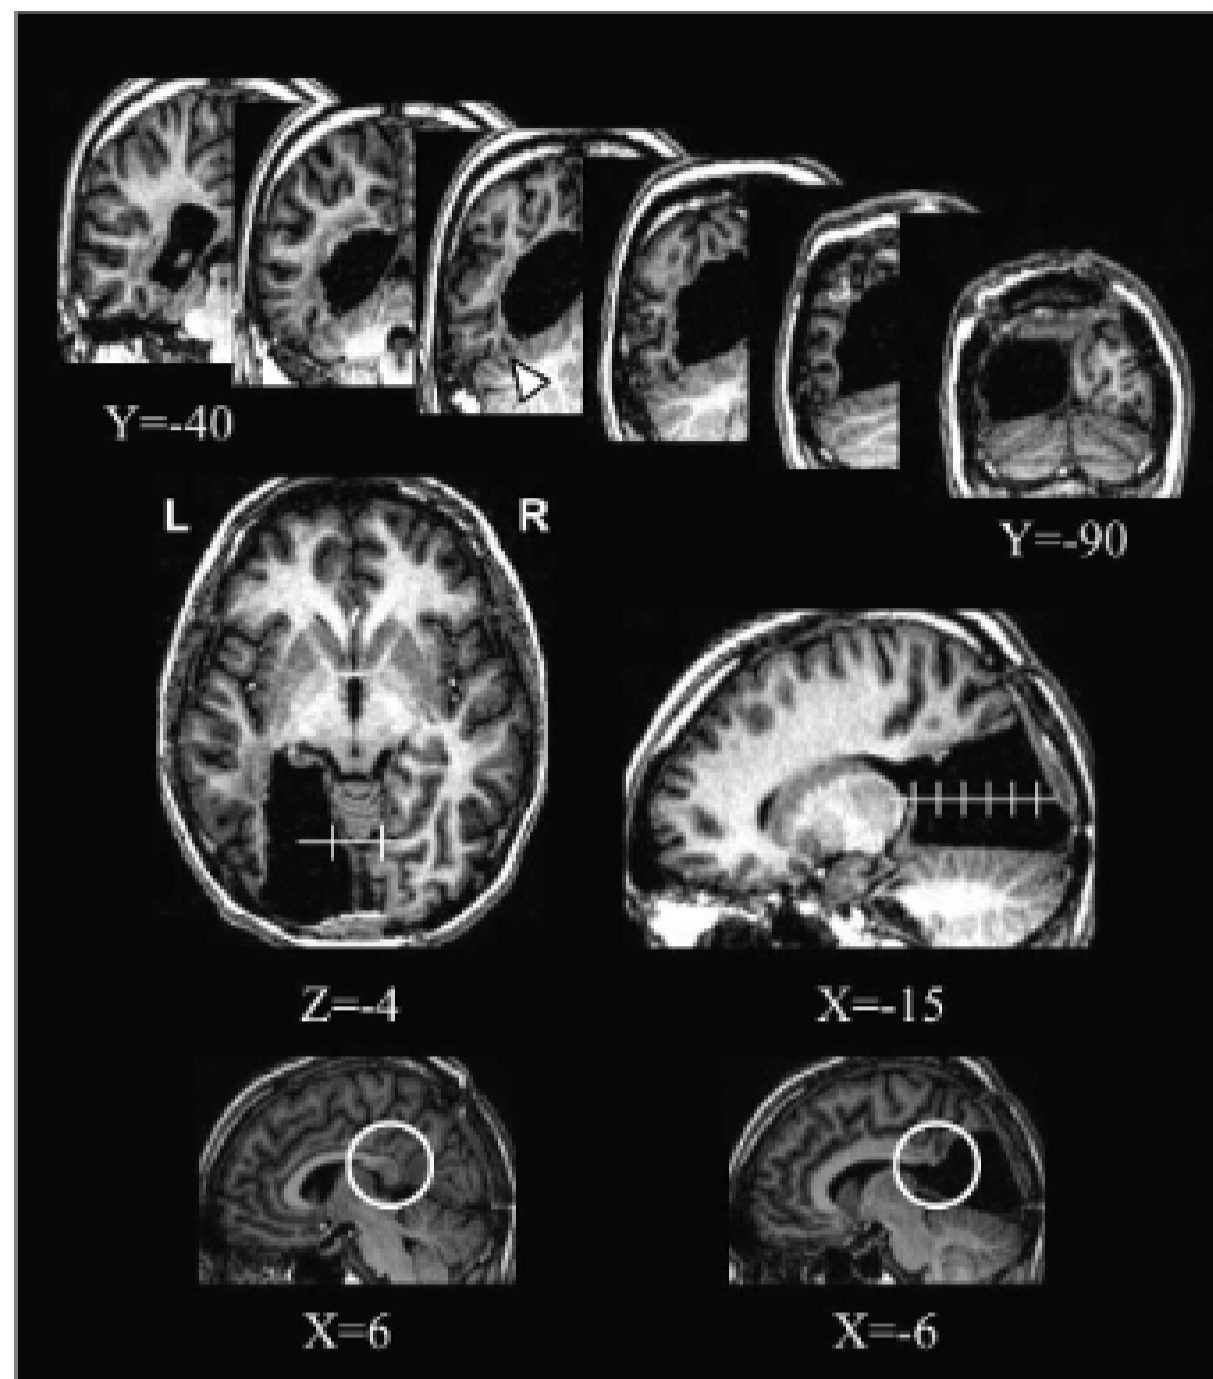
Normalized T1-weighted MRI of patient C.Z., showing the surgical resection of most of the left occipital lobe including the left half of the splenium, the posterior hemispheric white matter, the hippocampal and parahippocampal gyri. The white arrowhead points to the spared mid-fusiform cortex.
